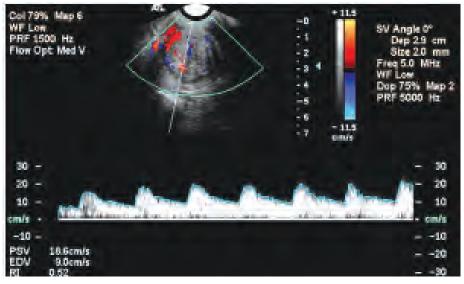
Pulsed Doppler waveform analysis demonstrated moderate vascular impedance blood flow signals at the periphery of the uterine fibroid, typical of a benign uterine lesion
